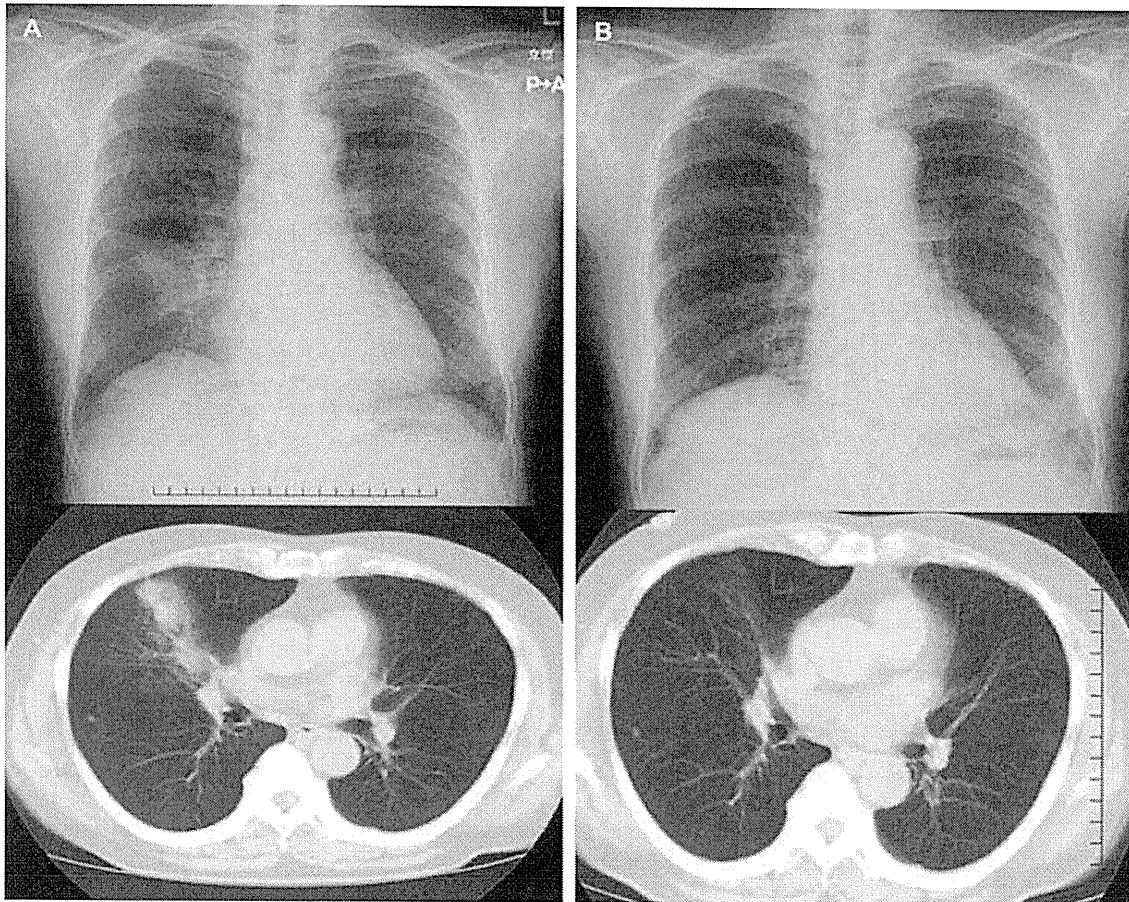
Imaging findings upon admission and after antifungal drug administration. (A) Chest X-ray shows infiltrates in the right middle lung field and computed tomography image shows segmental infiltrates at the right middle lobe. (B) Chest X-rays show absence of infiltrates after 4 months of treatment with antifungal agent.
